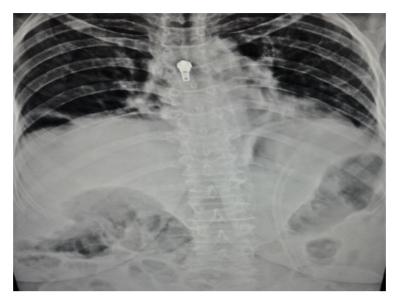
Chest X-ray, postero-anterior view, eight hours postoperatively, revealed complete inflation of the right lung.
